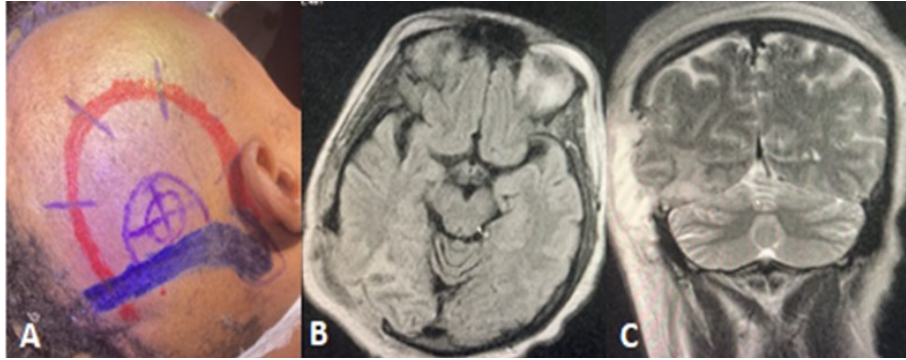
A: Topographical planning of the lesion located above the tentorium in direct relation to the transverse sinus. B, C: Magnetic resonance imaging of the skull, axial and coronal section, FLAIR and T2 weighting respectively, 5 days after surgery, showing total resection of the lesion.*
